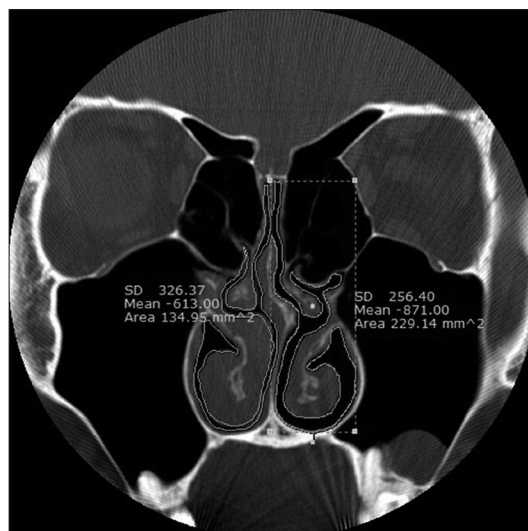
Examples of CT sections from scans were used to calculate the cross-sectional areas of the middle part of the nasal cavity. Numbers on figure refer to the standard deviation in Hounsfield units (first row), mean density (second row), and the measured cross-sectional area in mm² (third row).
